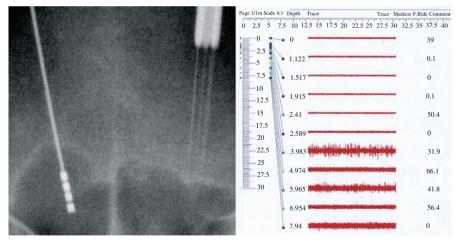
Microrecording and stimulating electrodes. During a one stage procedure, microrecording of the neural activity is obtained during the progression of a set of five microelectrodes (right side of the X-ray image), at different depths along the track. The STN target is recognized when the electrode records a high-frequency and high-amplitude spike activity (line 7 of the right image) after the neural silence typical of the Internal capsule (6 first lines). The activity of the SNr is found deeper (line 9) and corresponds to the lower boundary of the functional target. The corresponding microelectrode is then replaced by a chronic tetrapolar stimulator electrode (left side of the X-ray image) corresponding to white matter, the first one between zero and 2 to 3 mm below the AC–PC plane (subthalamic area and anterior zona incerta), the other one between 9 and 11 mm corresponding to the white matter just above the substantia nigra reticulata (SNR). SNR neurons fire in regular, symmetrical, large amplitude spikes, generally unresponsive to external stimuli (Fig. 3).
